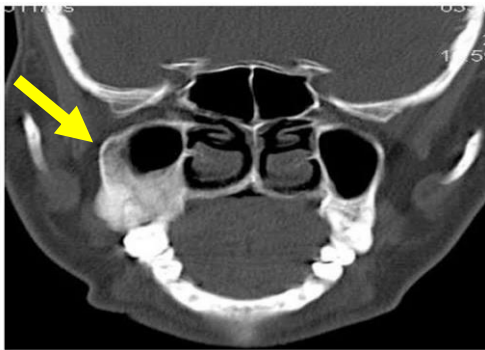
CT PNS showing right maxilla bony thickening.
